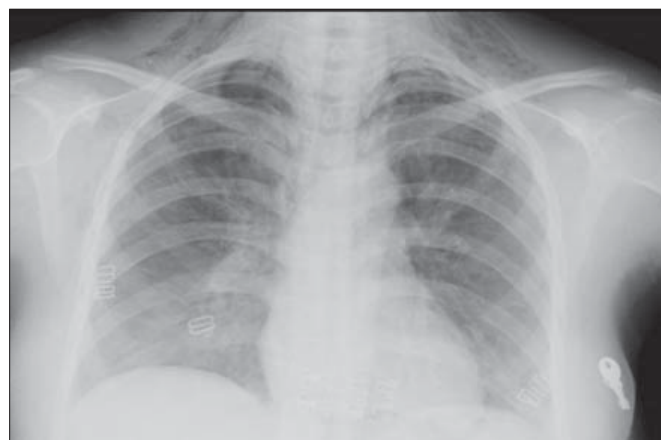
P-A chest X-ray showing subcutaneous emphysema in the neck.
